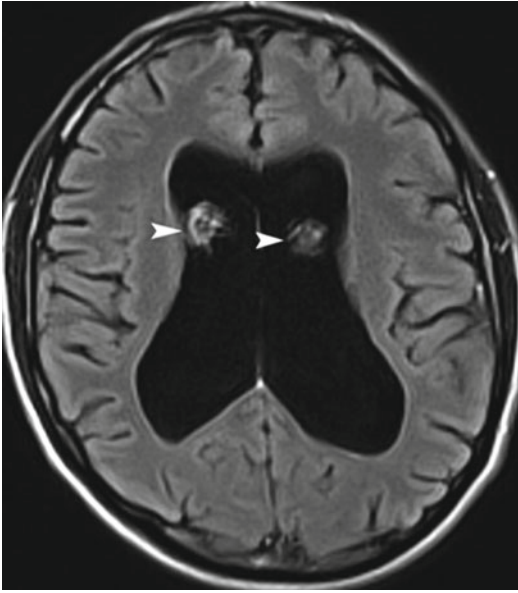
CSF flow artifact. A 42-year-old patient with noncommunicating hydrocephalus. Axial FLAIR image through the lateral ventricles demonstrates the focal increased signal (*arrowheads*) within the lateral ventricles above the foramen of Monro, due to flow-related entry-slice phenomenon
